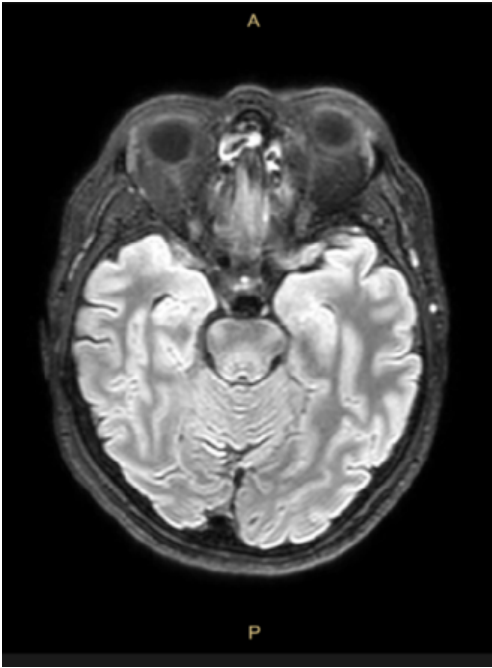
MRI of the patient, showing pontine hypotrophy compatible with the clinical findings of right hemifacial emiatrophia and left ataxia.
